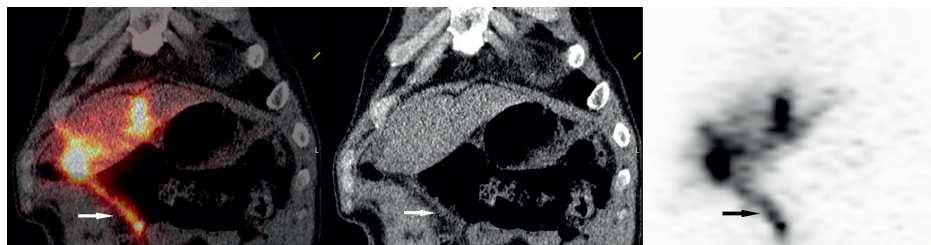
Figure a-c show extrahepatic deposition in the falciform ligament (arrows) in a 53-year old patient with hepatic metastases of a neuro-endocrine neoplasm who was treated with ^{166}Ho -radioembolization. Figures 8a-c show the ^{166}Ho SPECT/CT, the low dose CT and a planar image of the ^{166}Ho SPECT/CT.
